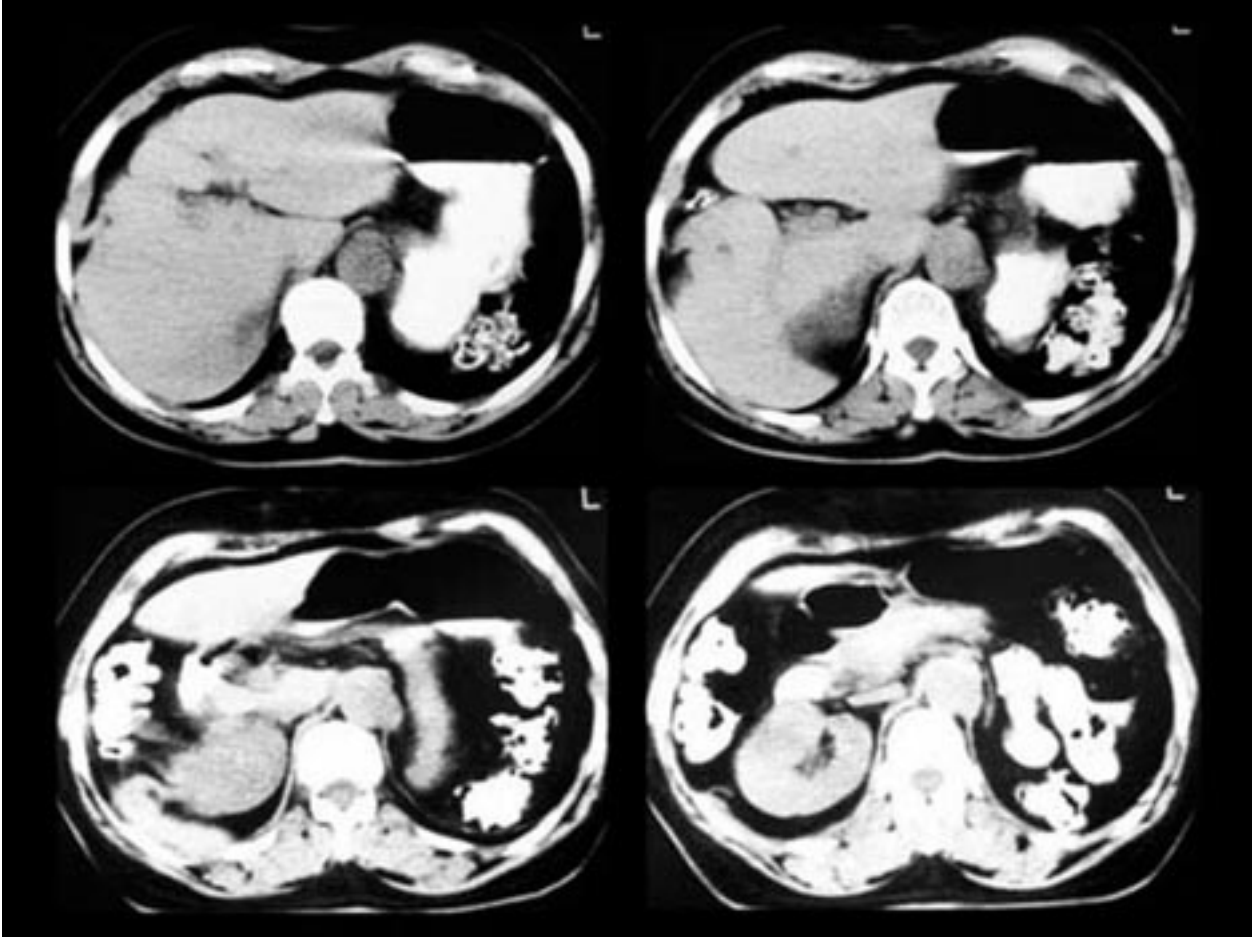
(A-D). Postoperative consecutive noncontrast CT images.
